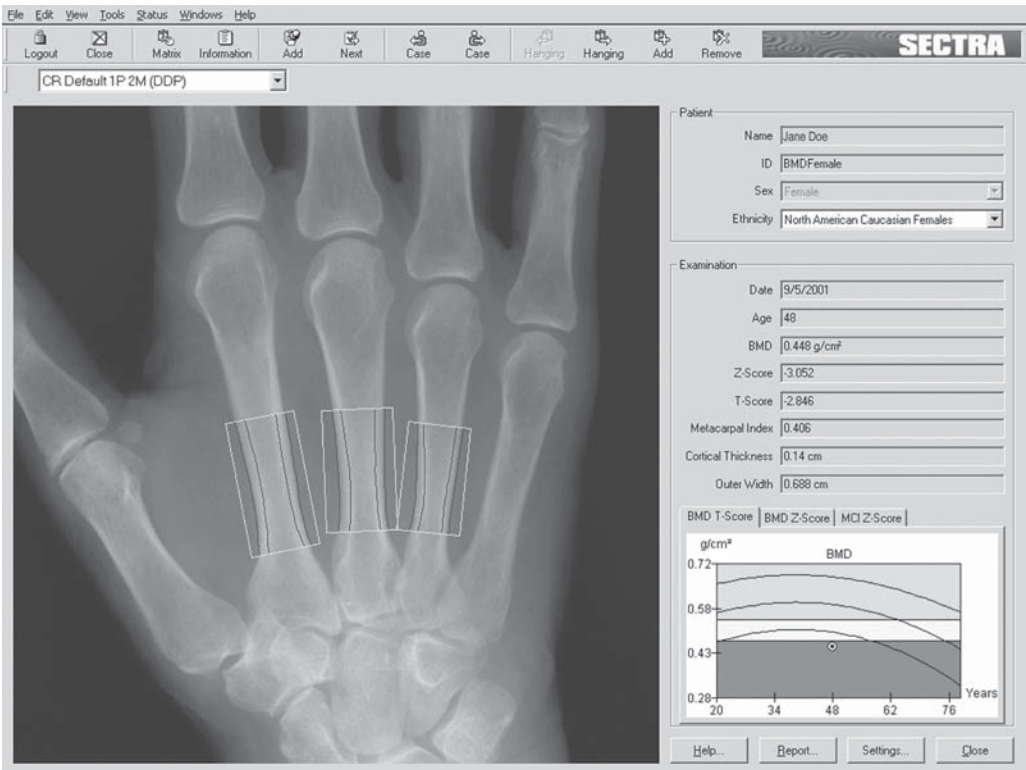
An X-ray image from computer-assisted radiogrammetry of the metacarpals of the index, long, and ring finger. Case provided courtesy of Sectra Pronosco, Denmark.
